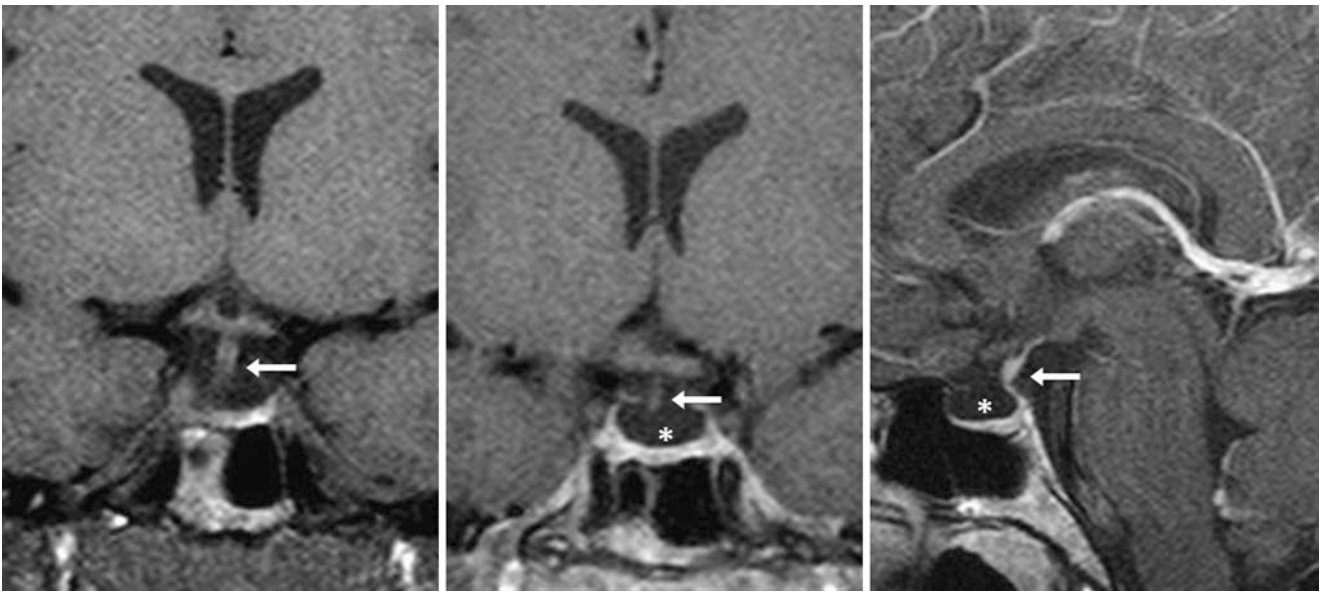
A 34-year-old female soon after trauma (but no brain injury) with a 1.5 T MRI that depicts normal mild infundibular shift to the right (*arrow*) on noncontrast coronal T1WI (*left*) and on postcontrast coronal
